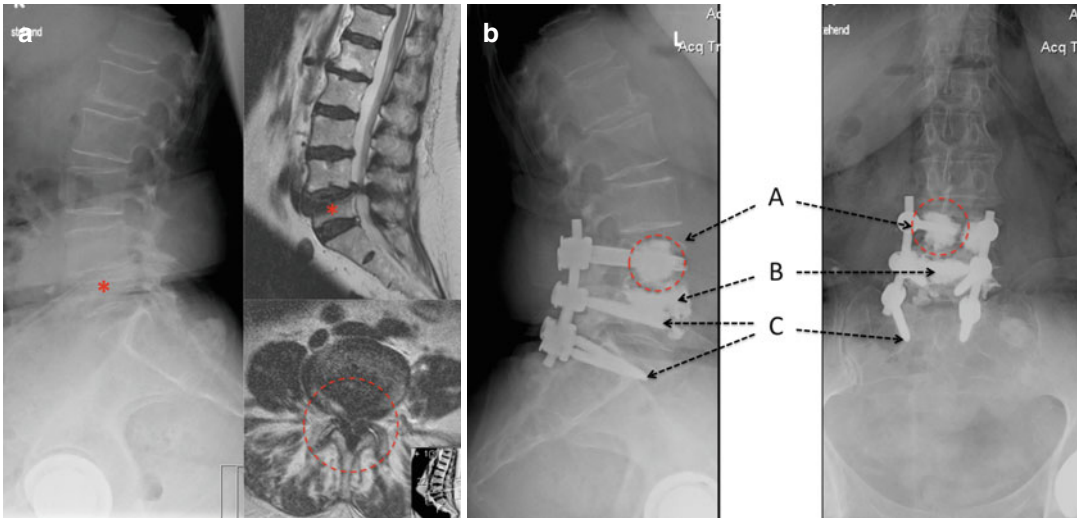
A 84-year-old obese female in good health. Spontaneous fracture of the L5 vertebra occurred with simply sitting. The patient noted acute onset of bilateral leg pain when sitting or standing. (a) Standing plain radiographs revealed a mild compression fracture of the L5 (*asterisk*) that was confirmed on MR with evidence of bony edema. Spinal stenosis was present. (b) Treatment
